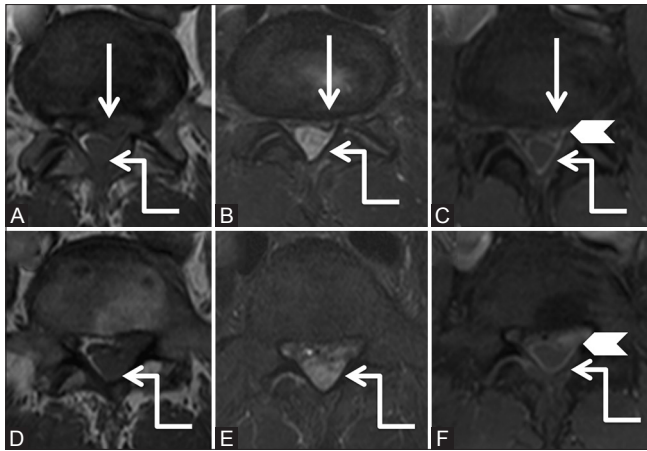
(A-F): Degenerative: Herniated disc: Axial T1-weighted (A, B), T2-weighted (C, D) and post-contrast T1 fat saturated (E, F) images at the level of disc (proximal row) and a level inferior to it (distal row) show diffuse disc bulge with left paracentral extrusion (arrow). Note tract-like enhancement (arrowhead) extending from the disc to peripherally enhancing soft tissue lesion in the posterior epidural space (elbow arrow) suggestive of disc herniation
